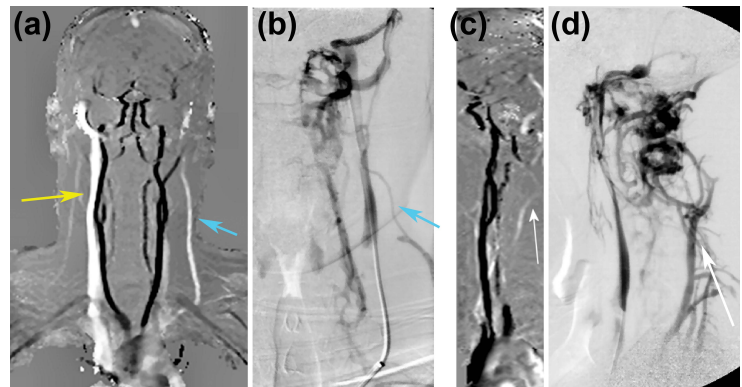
4D flow projection angiogram (VW-PCA) images in a 39 year old man with multiple sclerosis (white = superior-to-inferior flow). (a) In AP view, the right IJ is widely patent (yellow arrow), but the left IJ is diminutive. There is a large left-sided external jugular vein (blue arrows). (c) On lateral view, prominent posterior epidural venous collaterals are also visualized (white arrows). Conventional venograms following injection of the left IJ in the (b) AP and (d) lateral projections confirm the MRI findings.
